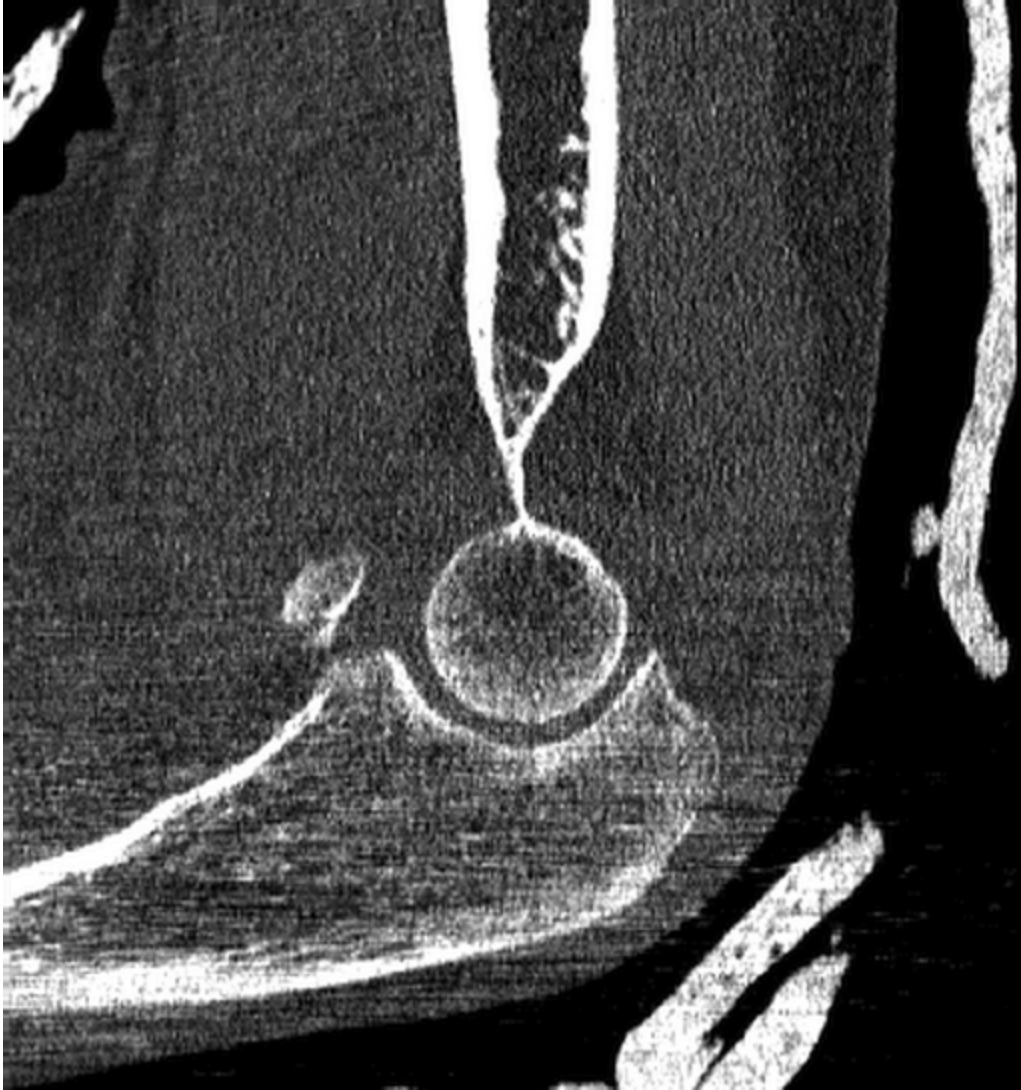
Sagittal CT reconstruction demonstrating a coronoid tip fracture.
